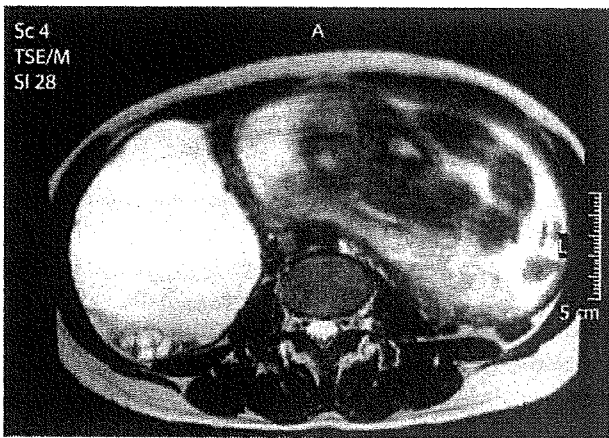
Magnetic resonance imaging demonstrated a cystic tumor containing a solid component (T2-weighted magnetic resonance image).
